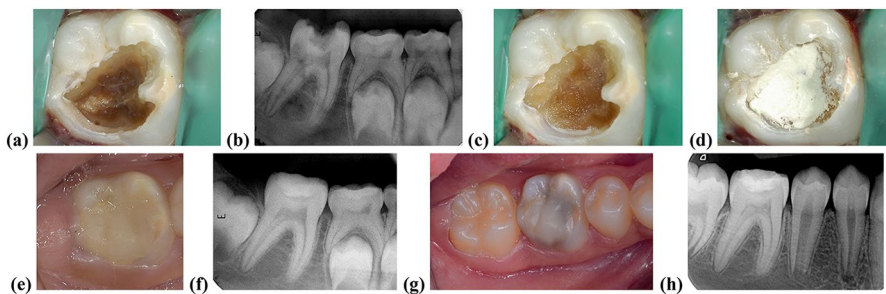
Clinical procedure of selective removal of carious tissue to firm dentine in a young permanent tooth. a Preoperative occlusal view showing moderately deep occlusal carious lesion in tooth 46. b Radiograph showing moderately deep carious lesion with a definite layer of dentin over the pulp with no signs of periapical pathology. c Selective carious tissue removal to firm dentine in the floor of the lesion and to hard dentine in the periphery. d MTA liner placed on the floor of the lesion (optional step). e Final intracoronal restoration using RMGIC. f Postoperative radiograph. g Occlusal view of follow-up at 4 years shows stable restoration, healthy soft tissue, erupted premolars and second permanent molar. h Four-year follow-up radiograph showing arrest of the carious lesion and further root maturation
